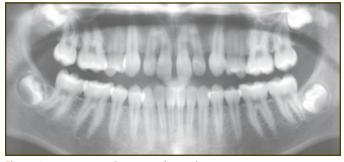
pre-treatment Panorex radiograph.
